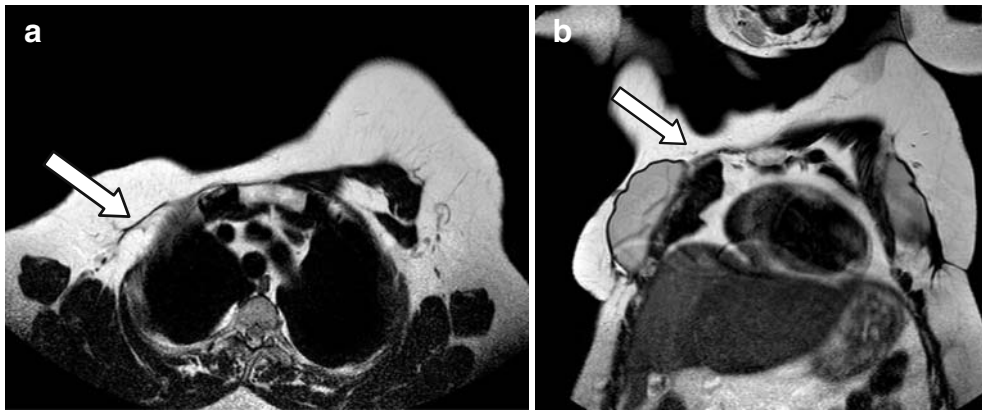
Case number 8544 of February 13th, 2009; 58 year-old patient, Halstead radical right mastectomy in 1996, reconstruction with implants in 2008; T2-weighted sequences in the sagittal (A) and coronal (B) plans showing the absence of the right pectoralis muscles (white arrows).
